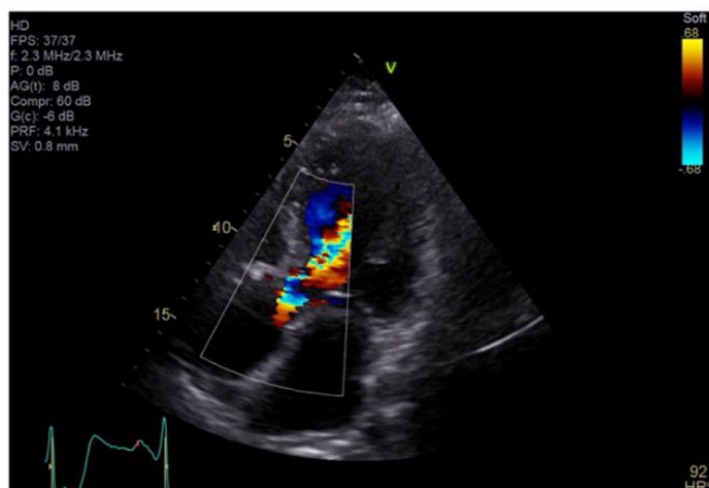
Bedside echocardiography showing 5-chamber view with relevant aortic insufficiency
